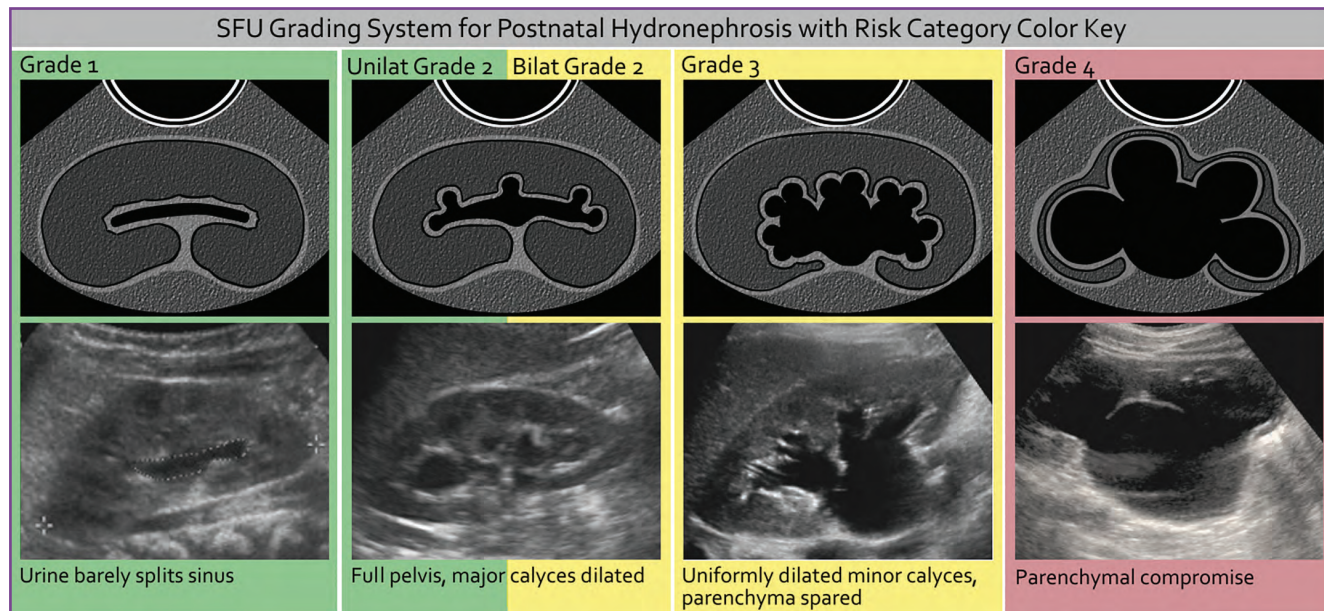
The Society for Fetal Urology grading system is based on renal ultrasonographic findings and uses a 5-point system (grades 0–4) to grade urinary tract dilation. The system is based on the degree of dilation of the collecting system and parenchymal integrity. Grade 0 is normal and not pictured. In grade 1, the urine splits the renal sinus. In grade 2, the urine fills the pelvis, and the major calyces are dilated. In grade 3, there are grade 2 findings plus dilation of the minor calyces and normal parenchyma. In grade 4, there are grade 3 findings, plus the parenchyma are thinned.
